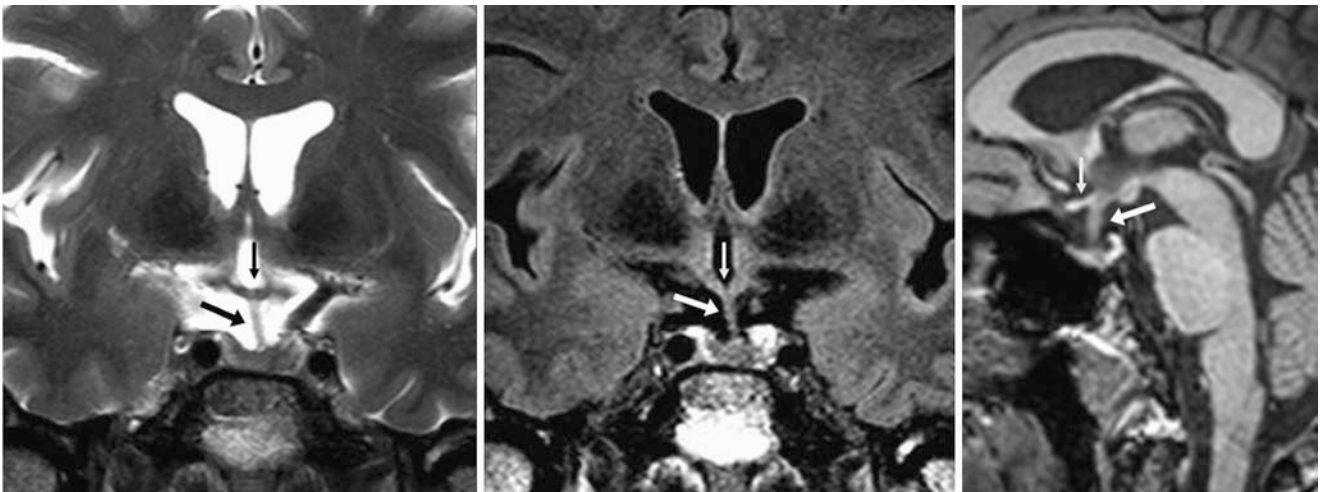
A 55-year-old patient with a 3 T MRI that demonstrated normal mild infundibular/stalk shift to the left (*arrows*), incidentally noted on coronal T2WI (*left*) and FLAIR (*middle*). The stalk appears normal
